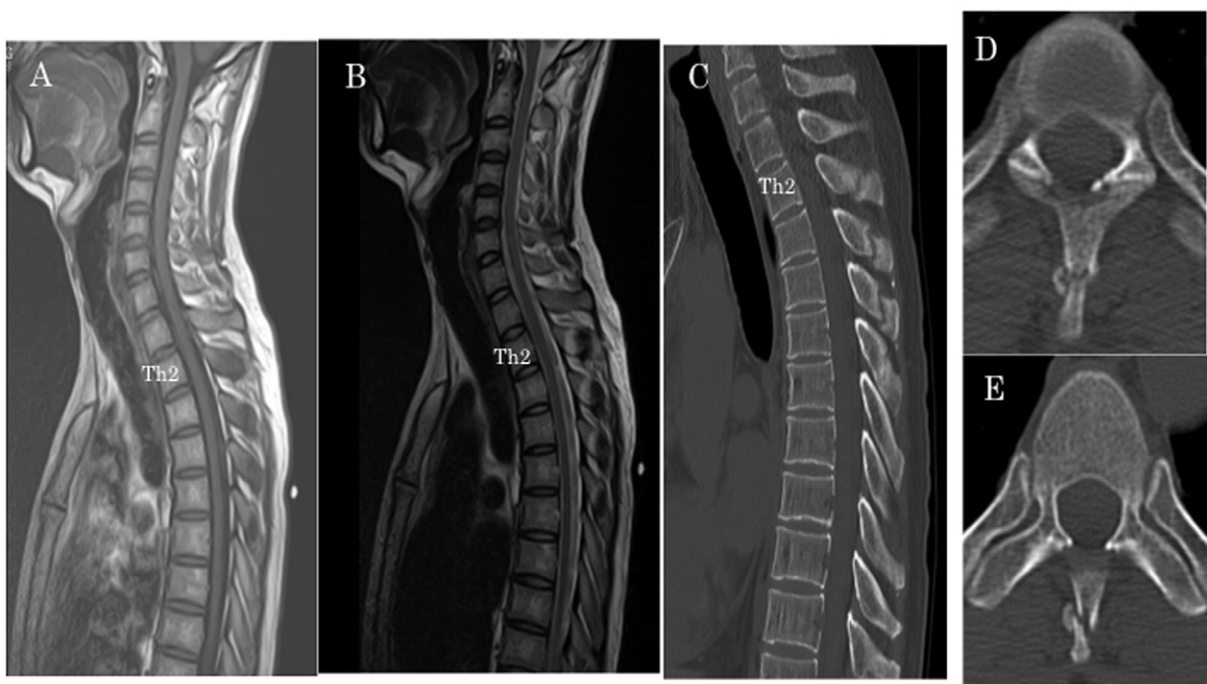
Sagittal MR image of cervical spine 2 months after trauma shows spinous process fractures of Th2–4 (A: T1 weighted image, B: T2 weighted image). Spinal CT confirmed spinous process fractures of Th2–4 and no other abnormal lesion was detected (C: Sagittal image, D: Axial image at the level of Th2, E: Axial image at the level of Th3).
